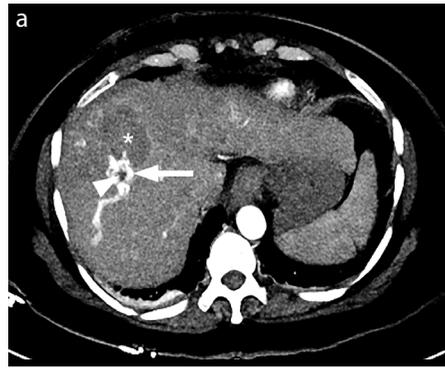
(a-d) Arterioportal fistula (APF) with exacerbation of portal hypertension. Massive hematemesis due to esophageal variceal bleed after microwave ablation of a segment 8 hepatocellular carcinoma. Axial (a) and coronal (b) maximum intensity projection contrast-enhanced computed tomography in the arterial phase demonstrates opacification of the right portal vein (arrow) adjacent to the ablation site (asterisk) due to APF. A non-occlusive thrombus in the opacified right portal vein is evident (arrowhead). The variceal bleeding was controlled with endoscopic band ligation. Angiogram (c) of the right hepatic artery demonstrates APF formation (arrows) with immediate opacification of the right portal vein (arrowhead). The APF was embolized with a mixture of histoacryl (n-butyl-2-cyanoacrylate) and lipiodol in a 1:2 ratio. Post-embolization angiogram (d) shows complete occlusion of the feeding artery with no evidence of APF.
